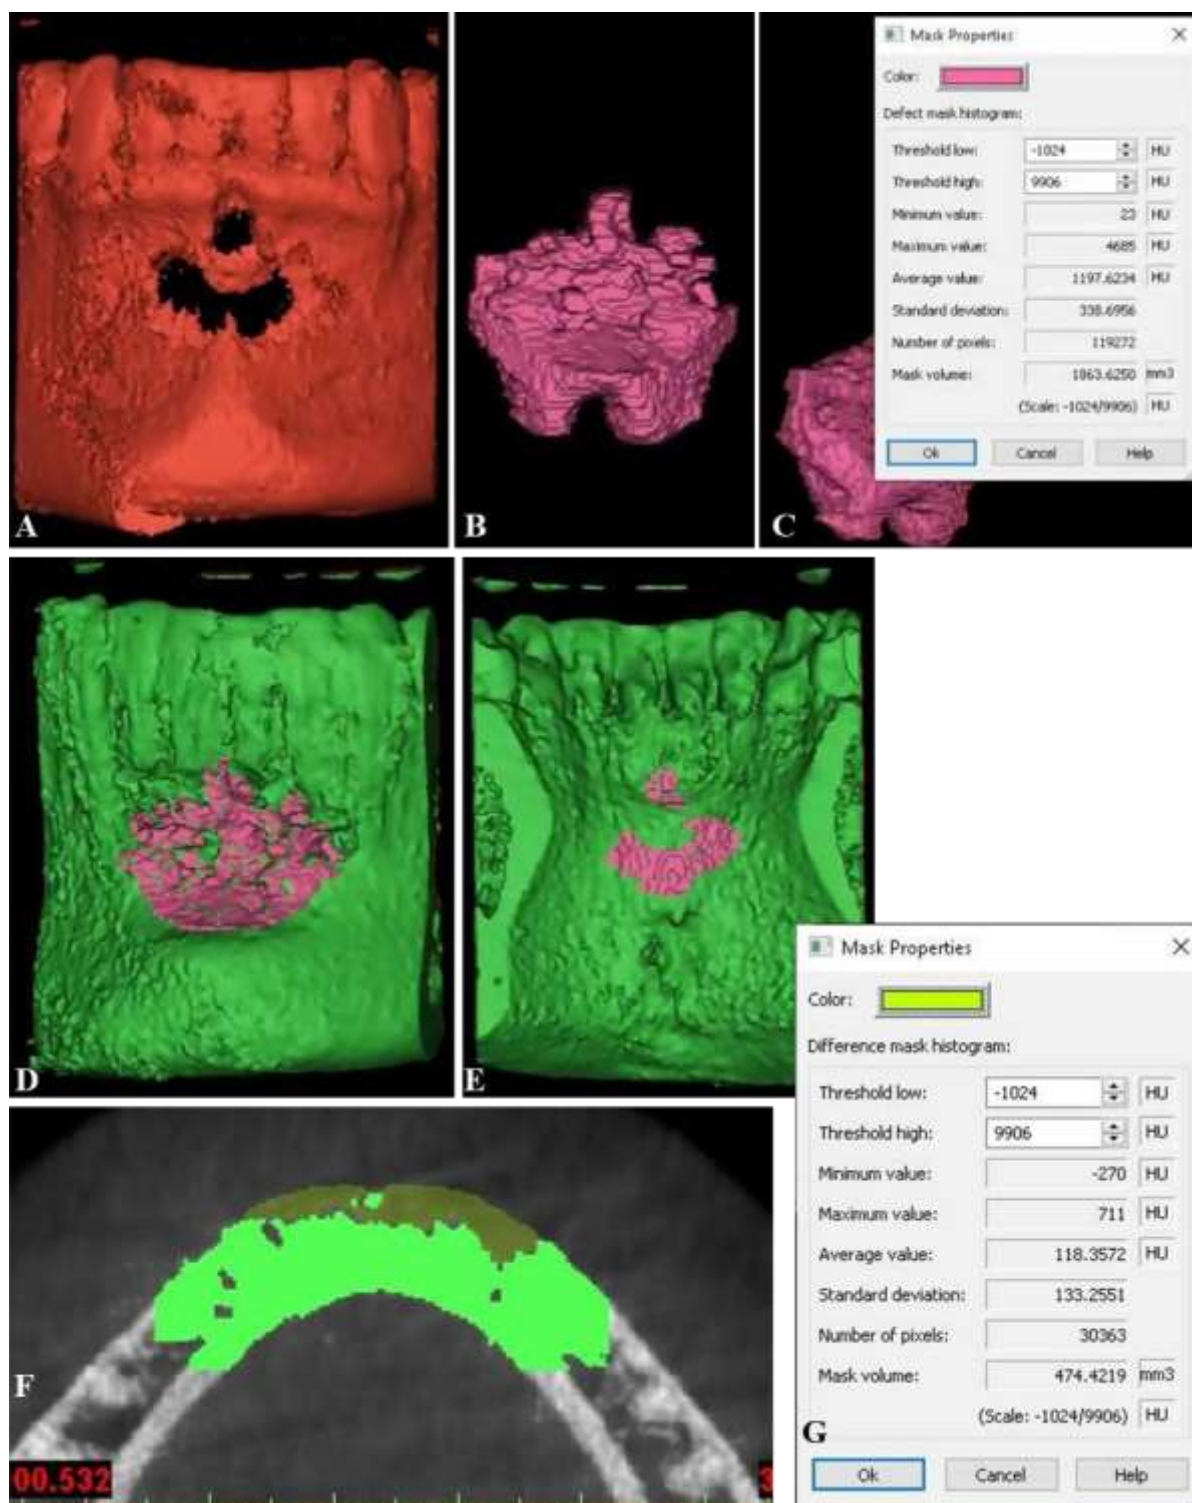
Examples of X-ray volumetric analysis.
